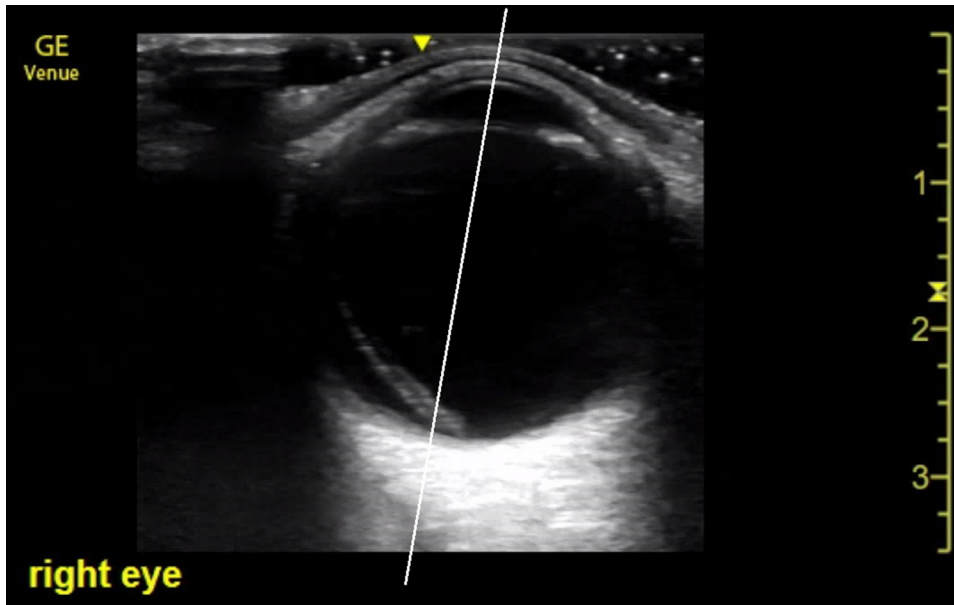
Ultrasound of right eye temporal retinal detachment crossing through pupillary midline (white line), detaching macula.
